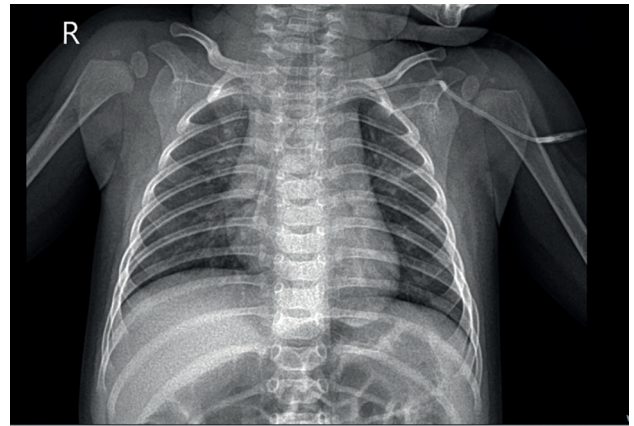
Chest radiograph showing bilateral multifocal pneumonia with first degree of thymus enlargement.
